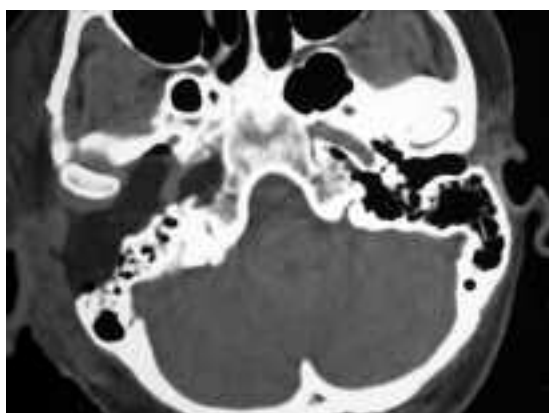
Post-operative CT scan (day 3) showing extension of right infra-temporal petrosectomy obliterated with abdominal fat.
